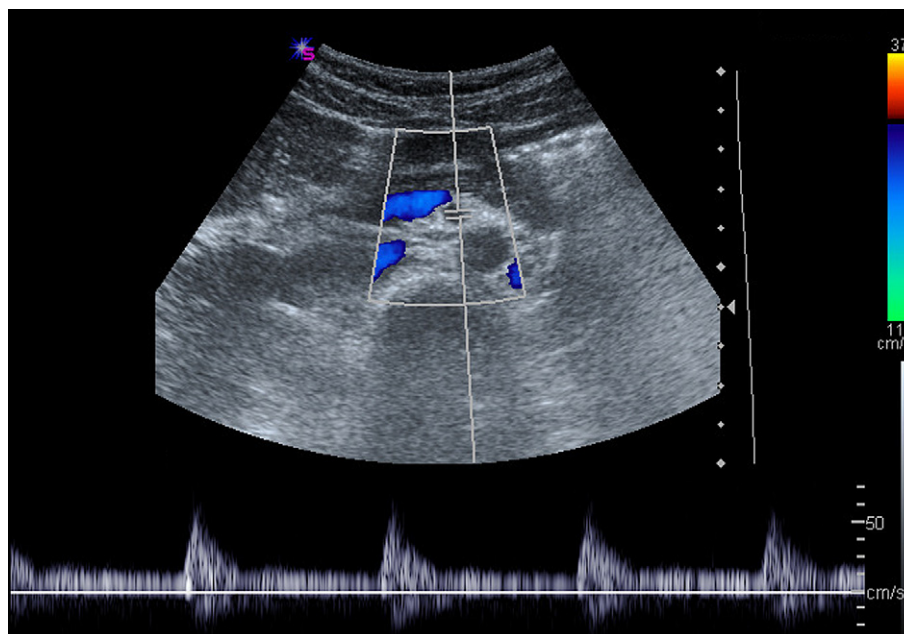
The Doppler tracing of the superior mesenteric artery varies depending on whether or not the patient is fasting. There is an appreciable diastolic component, which, along with the systolic peak, increases after a meal when the area supplied by the vessel is characterized by an increased demand for blood.
